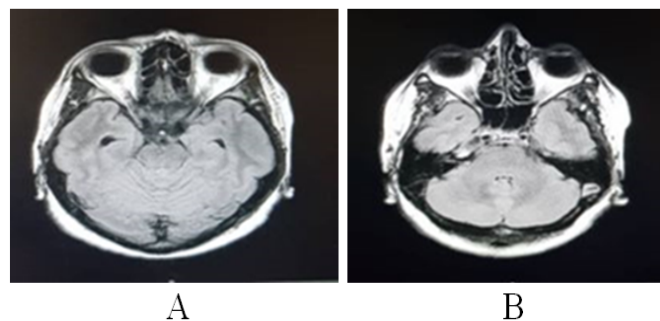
ControlFlair sequence brain MRI three months after the onset of symptoms showed novisible lesions (A and B).
